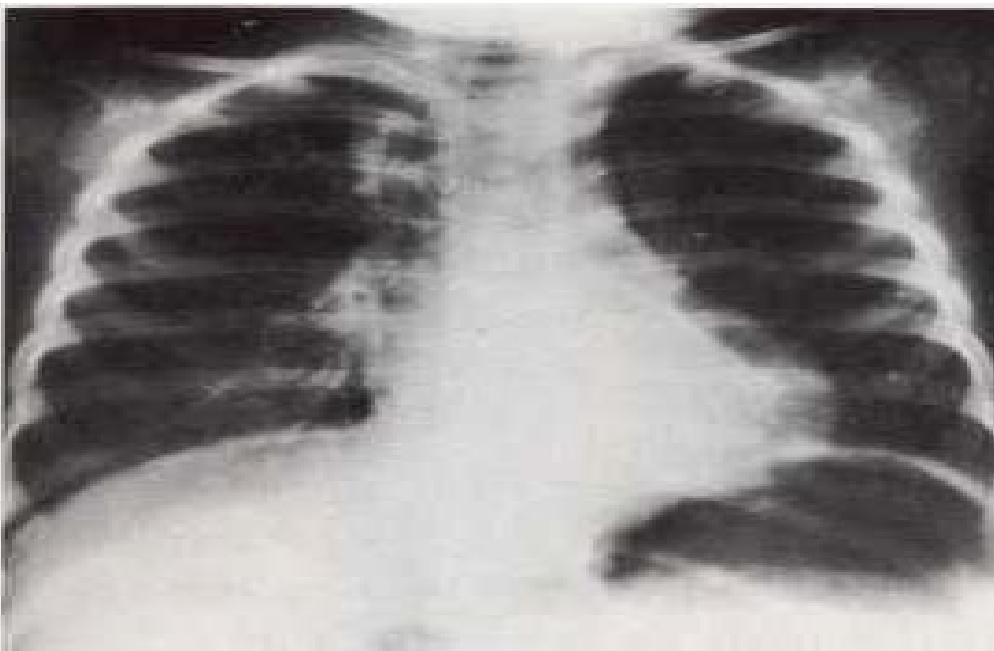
Chest X-ray of patient with pertussis.
